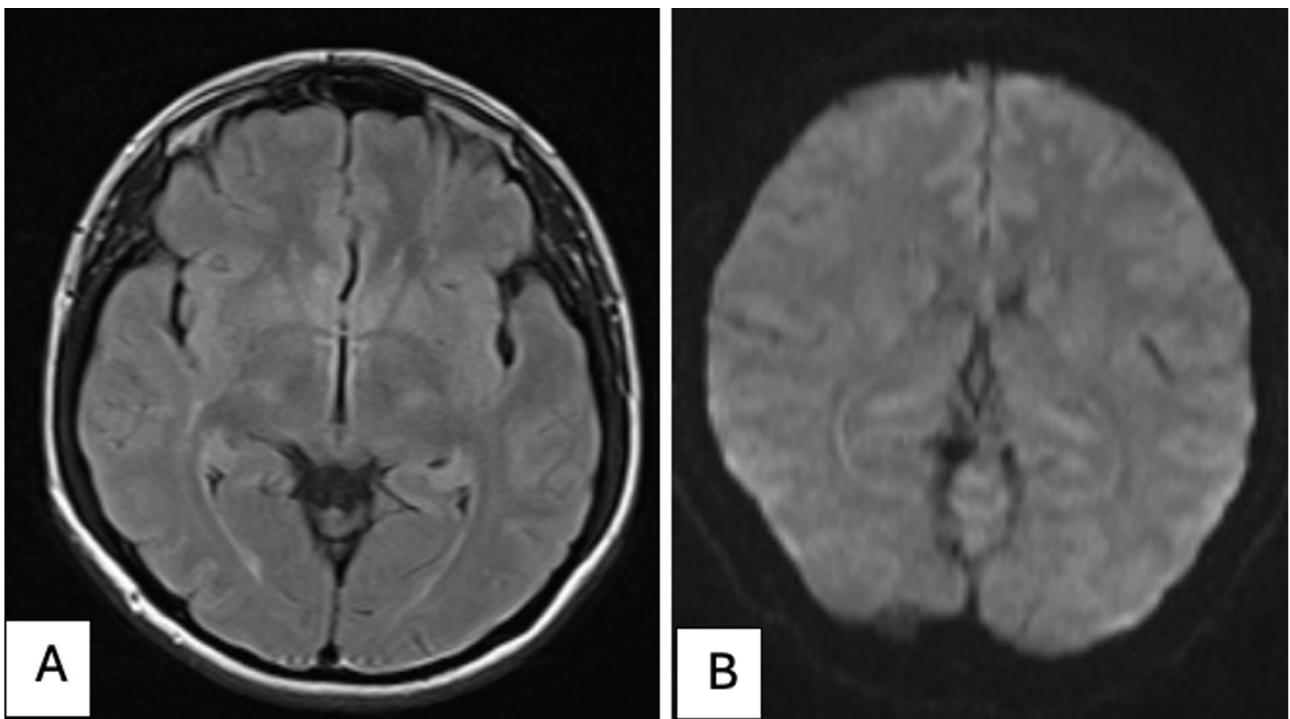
Magnetic resonance imaging (MRI) brain images. (A) MRI brain T2 image showing a normal brain with no infarct or haemorrhage. (B) MRI brain diffusion-weighted image showing no acute infarct.
